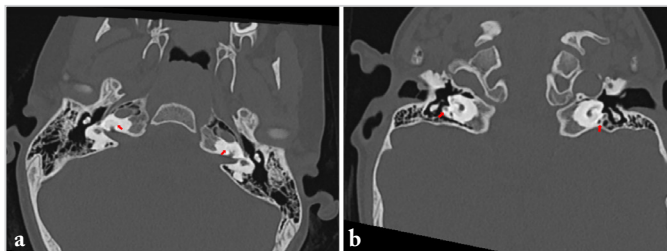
HRCT of temporal bones: a) axial cuts, and b) coronal cuts showing complete ossification of bilateral cochlea, and mild ossification of semicircular canals (red arrow)
